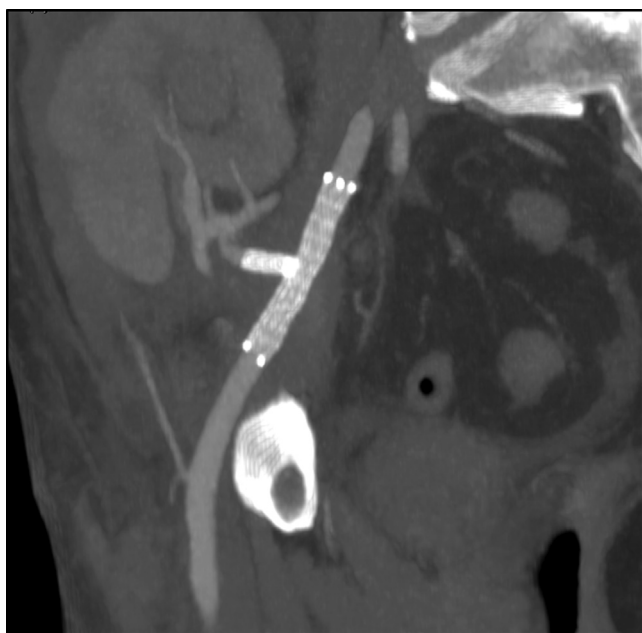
Postoperative computed tomography angiogram showing complete resolution of the thrombosis of the right external iliac artery and transplant renal artery.
